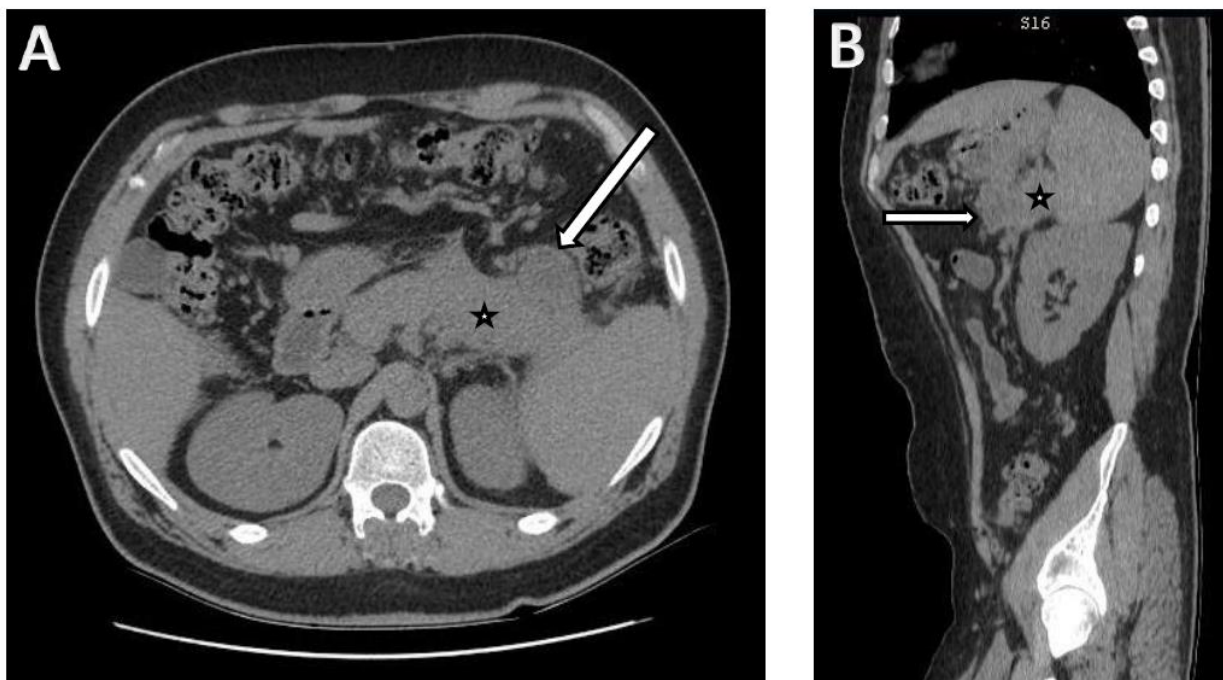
Figure 2. Axial (A) and sagittal (B) planes of CT scan of the patient's abdomen, 3 weeks after Evolocumab treatment, showing reduction of pancreatic inflammation (star) and the pancreatic pseudocyst (arrow) sizes.
